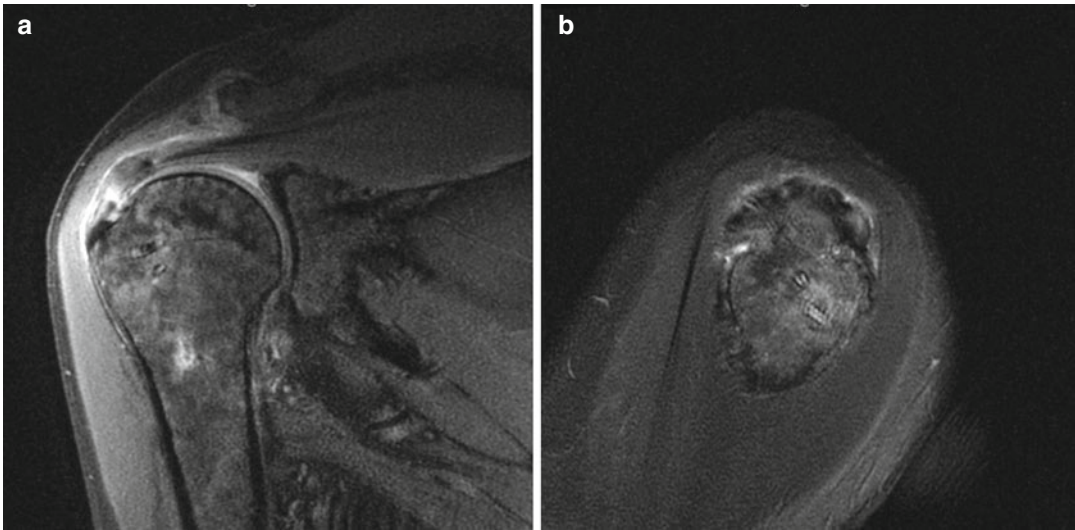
Coronal (left, a) and sagittal (right, b) MRI slices from a 54-year-old male showing intact rotator cuff repair 5 months postoperatively with increased signal at the area of margin convergence
